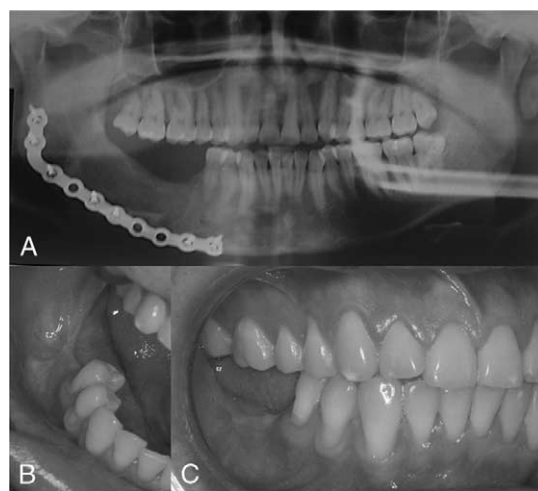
A, Panoramic radiograph 1 year postoperatively, showing good consolidation and adaptation of the bone graft. B, Intraoral clinical aspect with excellent tissue healing. C, Intraoral aspect of occlusion of the right side.
